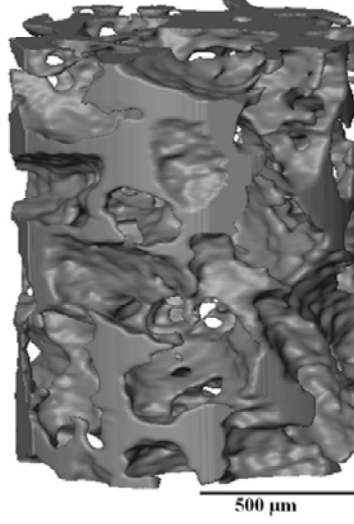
Reconstructed scaffold from μ CT (120).
